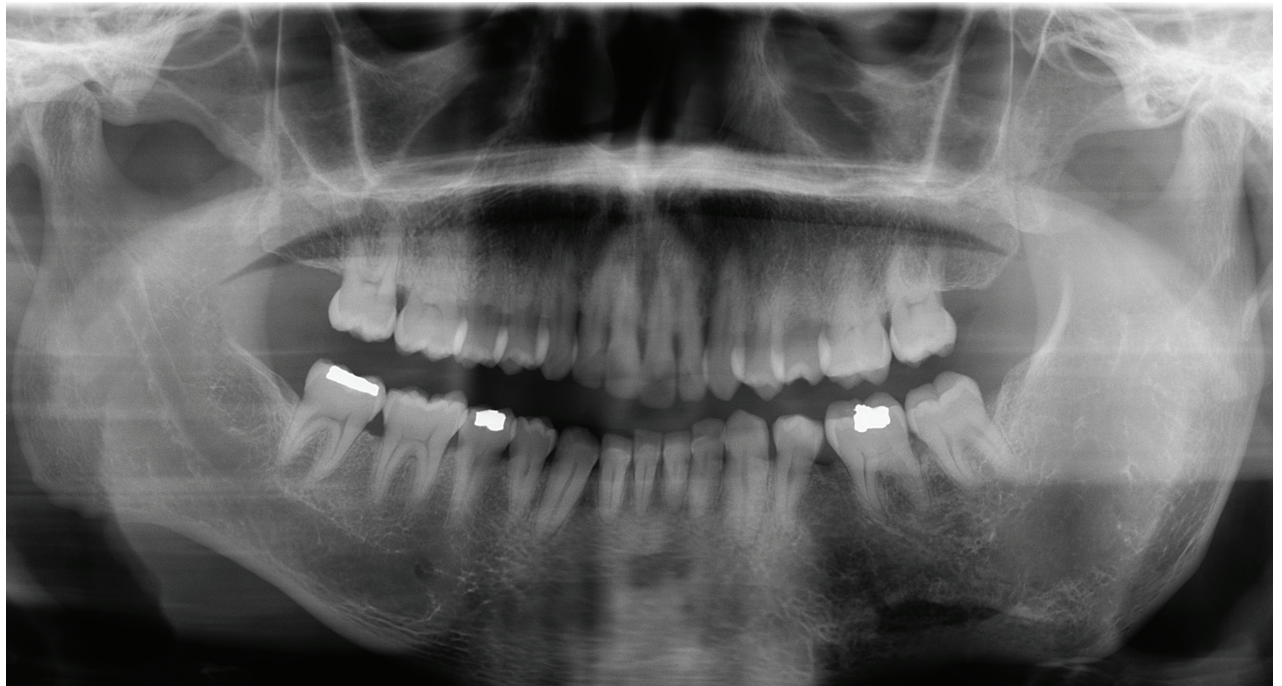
Panoramic radiographs of the patient 11 years ago (2012) at the age of 38 showing enlargement of the left ramus and corpus of the mandible.
